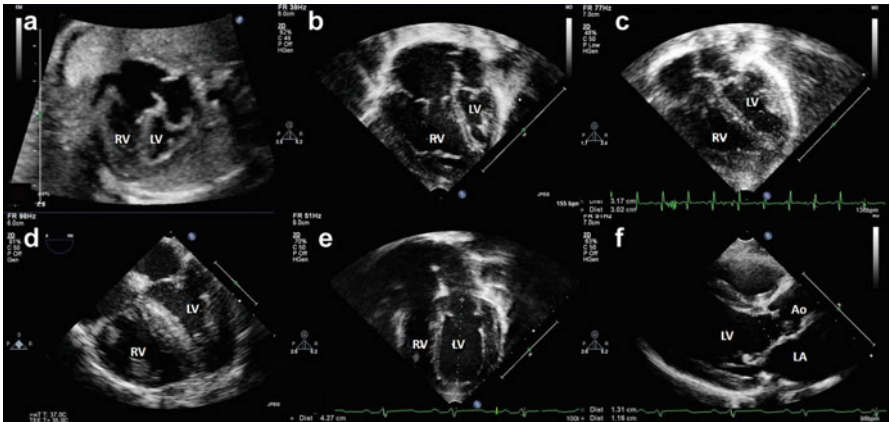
Progressive growth over time of a small left ventricle after successful fetal aortic valvuloplasty and maternal hyperoxygenation. (a) Pre-procedural aspect of a smaller left ventricle that does not reach the heart apex at 27 weeks of gestational age. The Z value of the LV length was -3.0 . Significant and diffuse endocardial fibroelastosis is also seen. (b) Slight improvement of left ventricular dimensions and function in the neonatal period prior to a hybrid procedure. (c) Unequivocal increase in left ventricular dimensions at 5 months of age. The left and the right ventricles contribute equally to form the heart apex. The Z value of left ventricular length was -1.5 . (d) Transesophageal echocardiography immediately after surgical overhaul of the left ventricular structures at 10 months of age. A normal-sized and functioning left ventricle is appreciated. (e) A normal left ventricular length (Z value -1.0) is seen at the age of 18 months. (f) Normal-sized left ventricle and a widely patent aortic valve is seen on long-axis view at the age of 3 years. *Abbreviations:* LV left ventricle, RV right ventricle, LA left atrium
